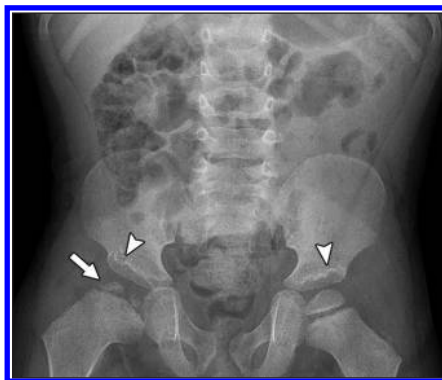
3-year-old boy with suspected Legg-Calvé-Perthes disease. A, Skeletal survey radiograph of pelvis shows multiple affected epiphyses with flattening of right proximal femoral epiphysis (*arrow*), irregularity of both acetabula (*arrowheads*), and flattening of multiple vertebral bodies. In addition, irregularity of metaphyses and epiphyses of multiple long bones bilaterally were also observed (not shown). B, Follow-up radiograph of right ankle obtained when patient was 10 years old shows progressive flattening and irregularity around physes, particularly involving distal tibia (*arrow*). Diagnosis of multiple epiphyseal dysplasia was made on basis of imaging findings and was confirmed by genetic testing. These findings contrast with those of dysplasia epiphysealis hemimelica, in which epiphyseal overgrowth occurs rather than epiphyseal flattening, as was observed in this case.
